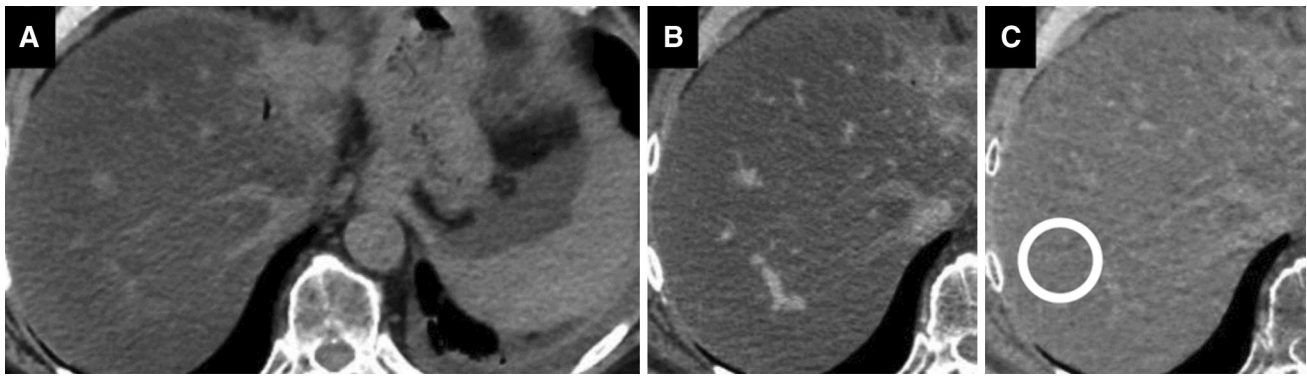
Hepatic steatosis assessed with DECT. Conventional unenhanced CT image a shows hypoattenuating liver parenchyma that measured -8 HU in density, compatible with severe steatosis. 70-keV monochromatic image b generated from DECT shows enhancing
